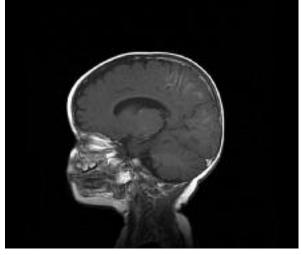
SE/T1 weighted MR image after enhancement – hyperintense linear areas in the cortex of parietal and occipital lobes (right side) suggestive of cortex passive hyperaemia.
